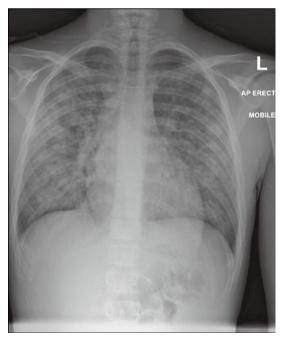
Chest radiograph on the day of admission
